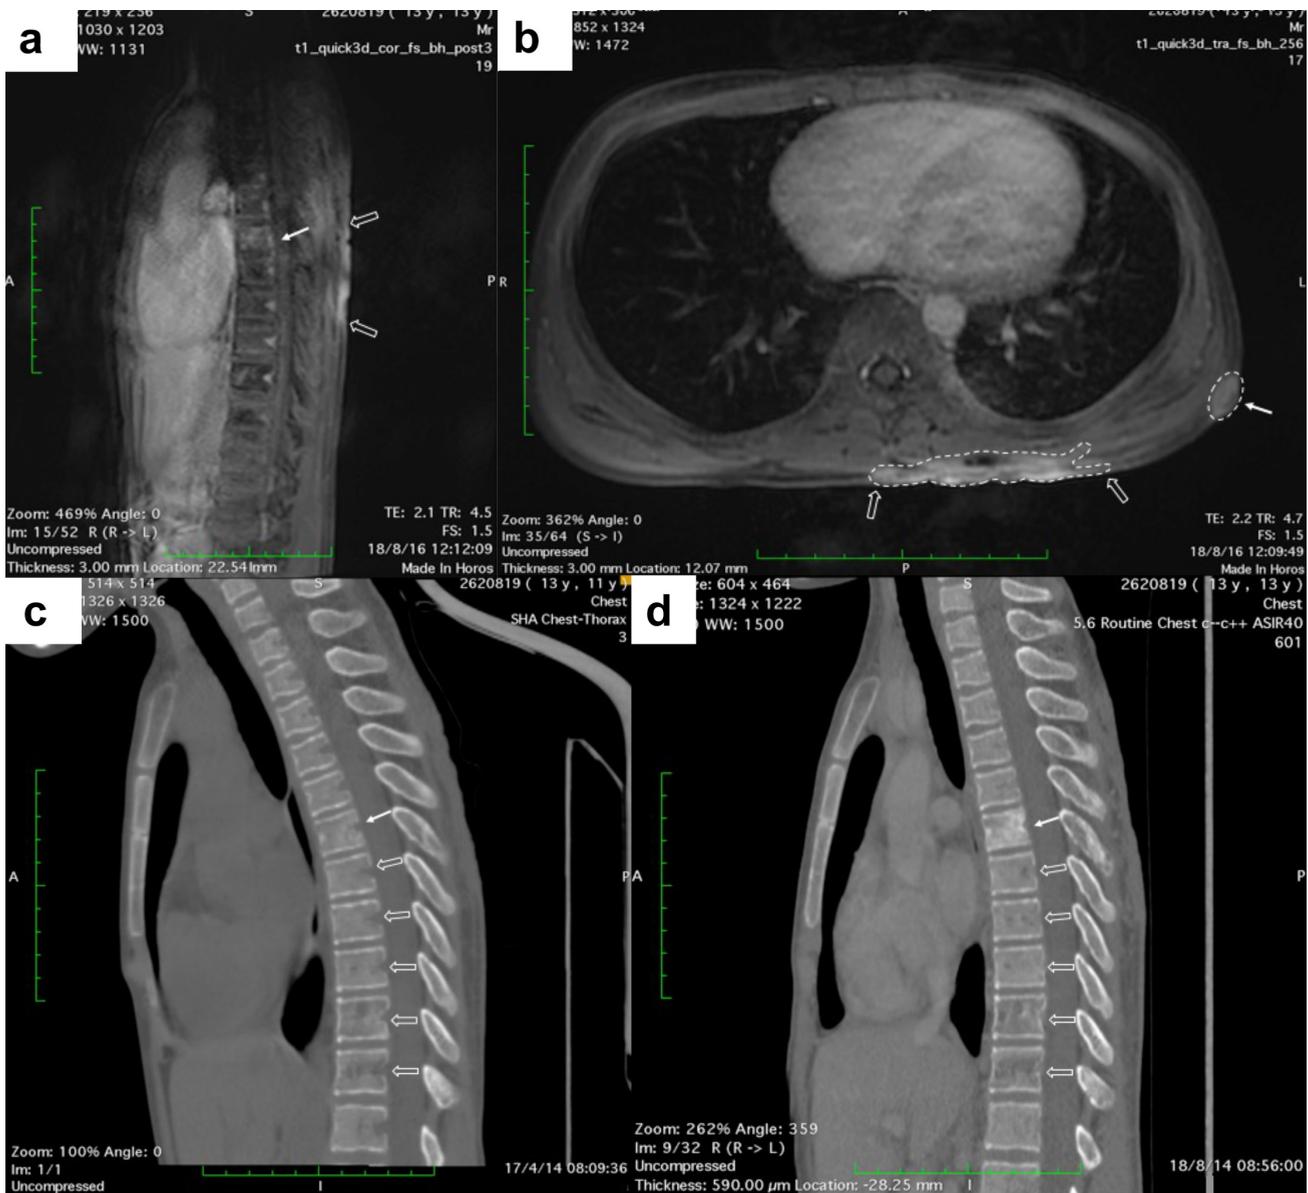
MRI and CT Radiological findings. Magnetic resonance images of the patient before the onset of sirolimus treatment (a-b). Transverse and coronal views of T1-weighted MRI with enhancement and fat-suppression sequence showed irregular margins and strong inhomogeneous enhancement of the mass on the midline of the upper back. Another isolated homogeneous mass with weak enhancement was also noticed in her left infrascapular region. The region of the lesions is highlighted by white arrows (a) and the dotted box (b). Coronal views of spinal CT in 2017 (c) and 2018 (d). CT scans in the sagittal plane of the patient’s thoracic spine from T1 to T12 show mixed lytic and sclerotic changes of T6 to T11 vertebral bodies. The solid white arrows indicate T6, where the puncture biopsy was obtained
